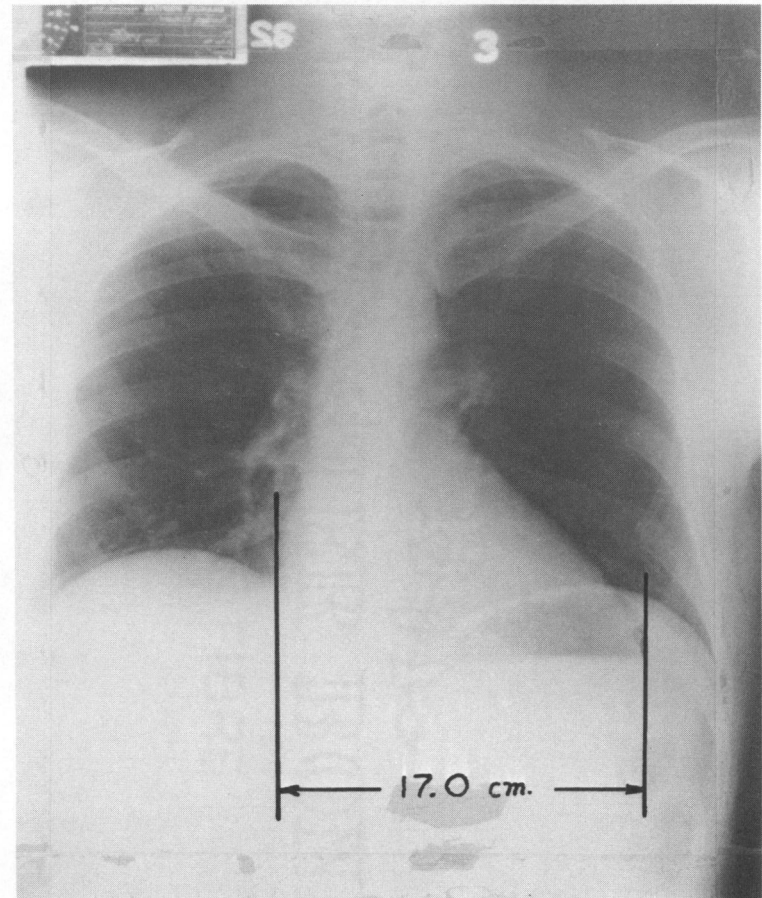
Radiograph of diastolic cardiac phase at maximum inspiration
